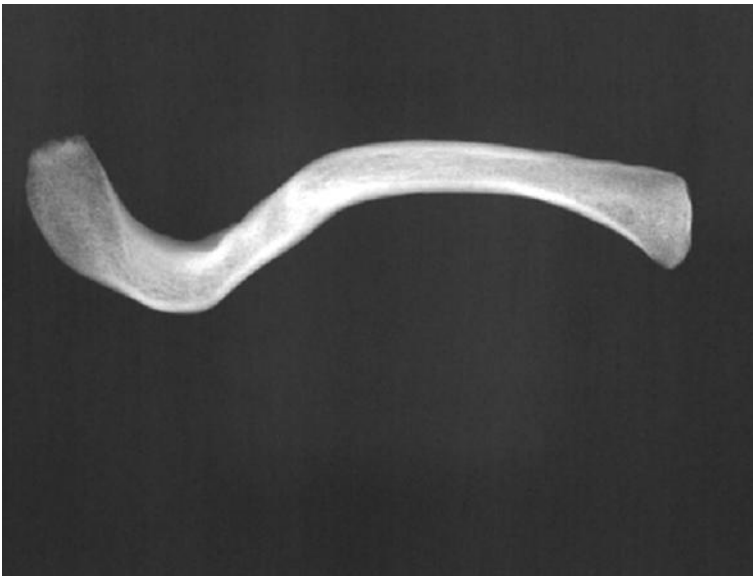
Radiograph of the fractured clavicle of skeleton 001 from Kastella
